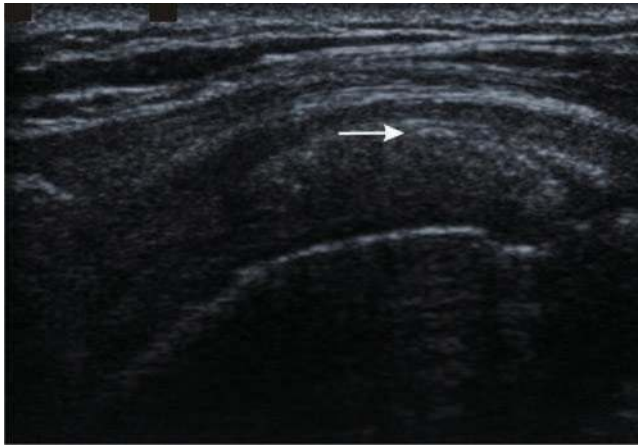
Rotator cuff calcification. Longitudinal ultrasound image of the supraspinatus tendon showing echogenic calcification within the tendon (arrow) without acoustic shadowing, a common feature of less mature tendon calcification.
